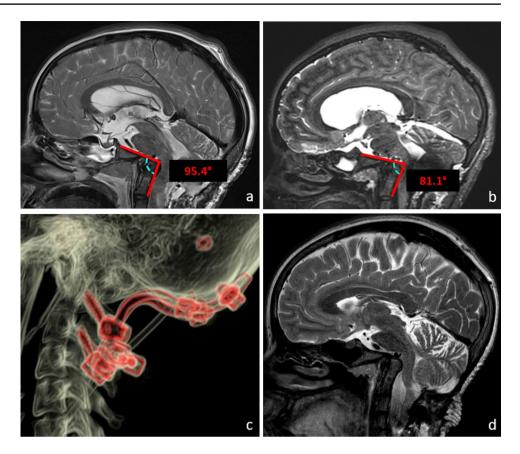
Preoperative MR images. a Clivo-axial angle. b Grabb-Oakes index. c Chamberlain line. d Harris measurement Fig. 2 a MR image before C2 laminectomy. b MR image after C2 laminectomy. c CT scan after craniocervical fixation. d MR image after craniocervical fixation
